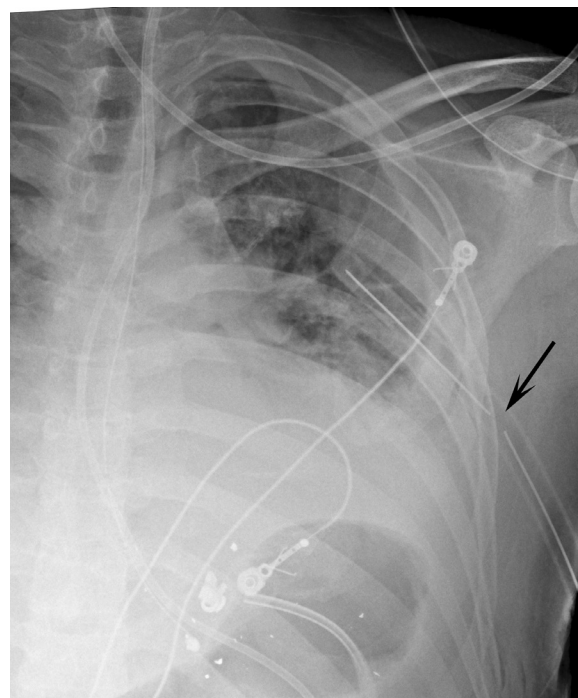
■ Anteroposterior (AP) supine chest x-ray. Left chest tube has not been advanced adequately with the side hole outside of rib margin (*arrow*).
